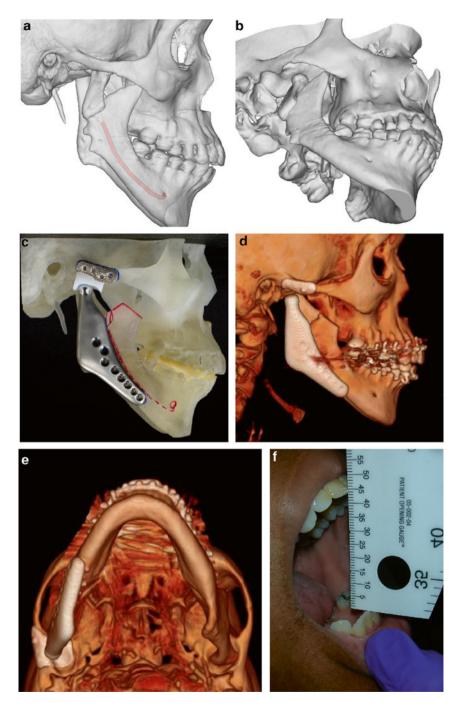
Case #2 delayed primary TMJ TJR reconstruction. (a, b) CT scan 3D reconstructions after failed modified condylotomy. Note the lack of bone stock in the mandibular ramus and the level of dislocation of the condylar segment. (c) Custom-made alloplastic TMJ prosthesis that included the creation of a new mandibular angle for mandibular symmetry. (d, e) Postoperative 3D CT scan reconstructions showing good prosthesis placement and achievement of mandibular symmetry. (f) Patient's postoperative maximum interincisal opening 9 months after the TMJ replacement surgery (*Source*: Vega LG, Gutta R, Louis P. Oral Maxillofac Surg Clin North Am. 2011;23(1):119–32)
